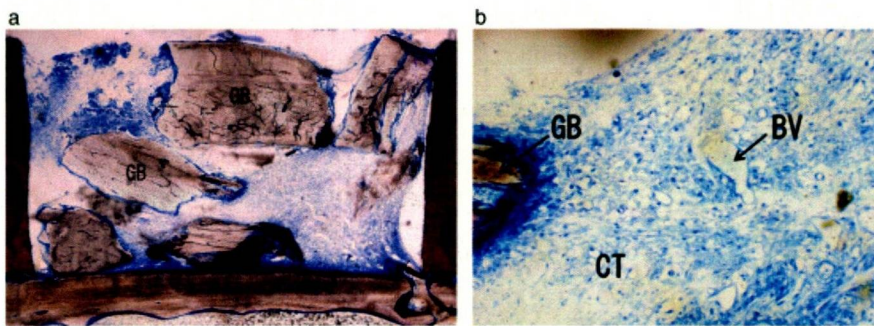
Large bone grafted site at 1 week. (a) Grafted bone (GB) was observed over the entire chamber. Bone resorption was not observed around the surface of GB at this time point. Magnification  $\times 2.5$ . (b) High-magnification image of (a). In the interspace of the GB, there was very loose fibrous connective tissue (CT), and a few blood vessels (BV) were also observed. Magnification  $\times 25$ .
